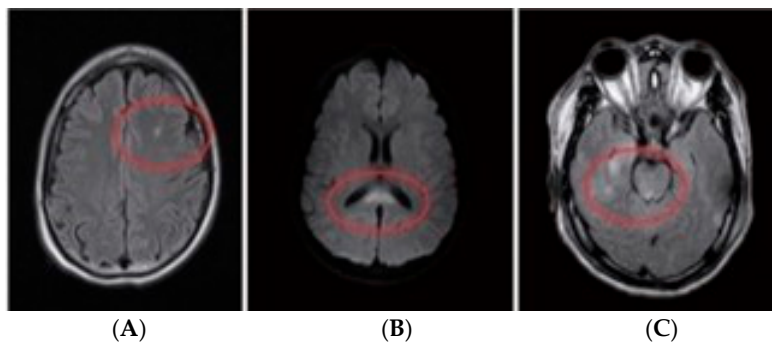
(A) MRI (axial image) shows small hemorrhage in frontal white matter and (B) hemorrhage in splenium of corpus callosum. (C) MRI image (axial view) showing hemorrhage in the rostral midbrain and medial temporal lobe. Source: Figure by authors.
